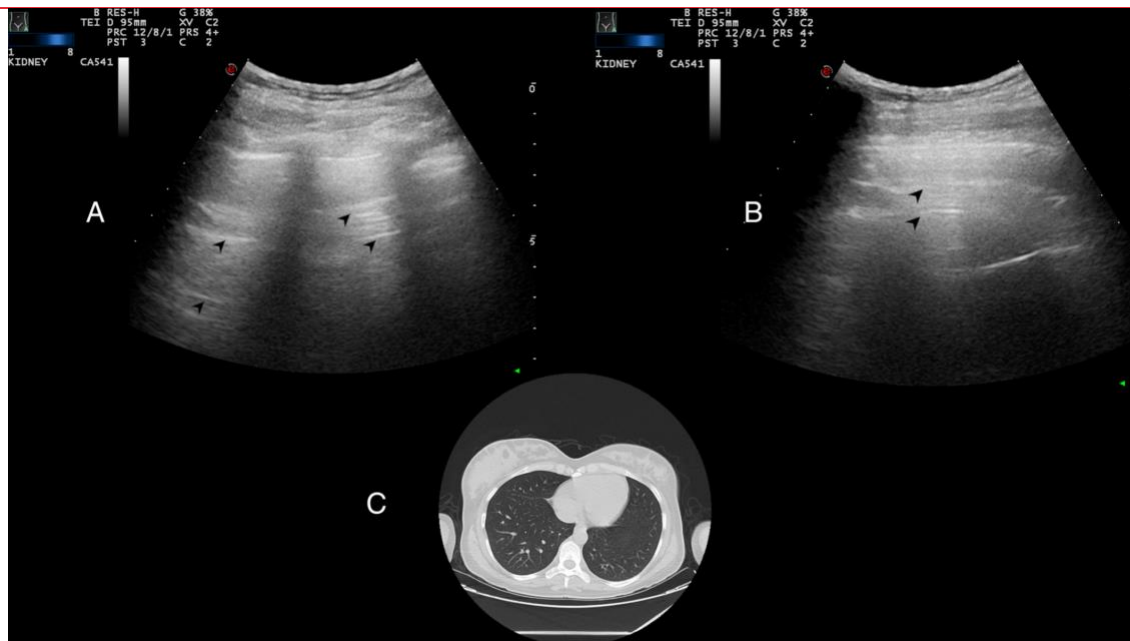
Normal LUS pattern with the convex transducer positioned longitudinally (A) and in the intercostal space (B). Arrowheads indicate horizontal A-lines at regular intervals. Normal CT findings do not indicate viral pneumonia (C).
